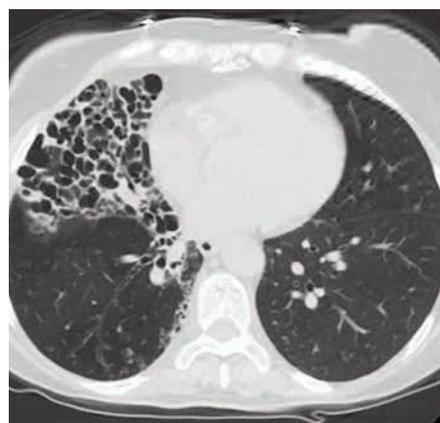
CT scan image demonstrating right middle lobe bronchiectasis associated with NTM infection, amenable to VATS resection.
